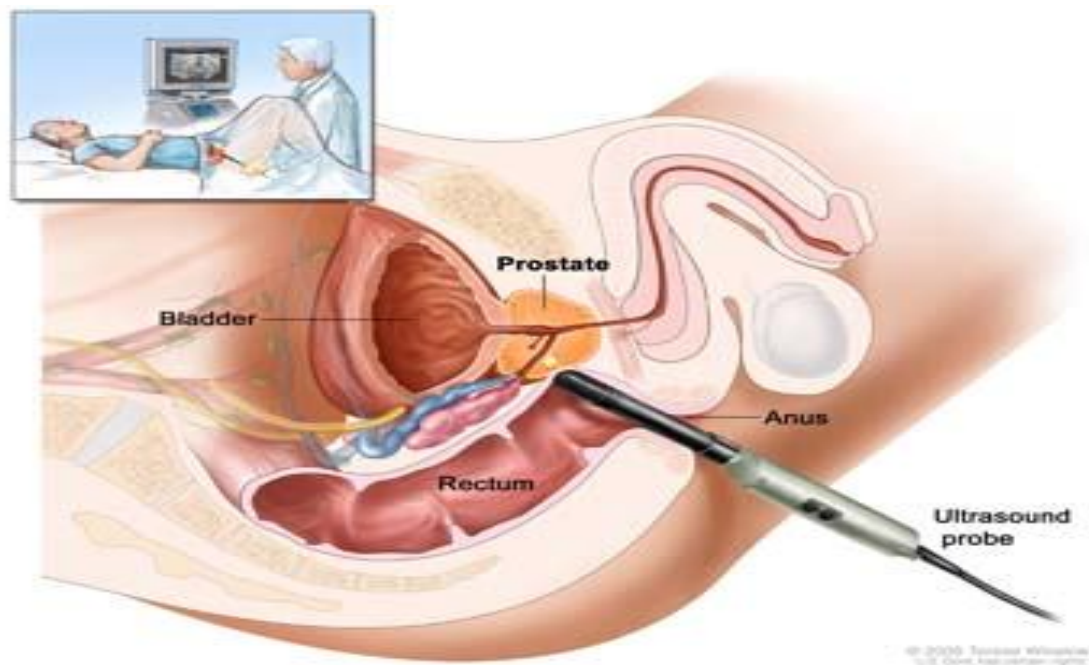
Shows transrectal ultrasound of prostate (Prostate cancer.2012)
